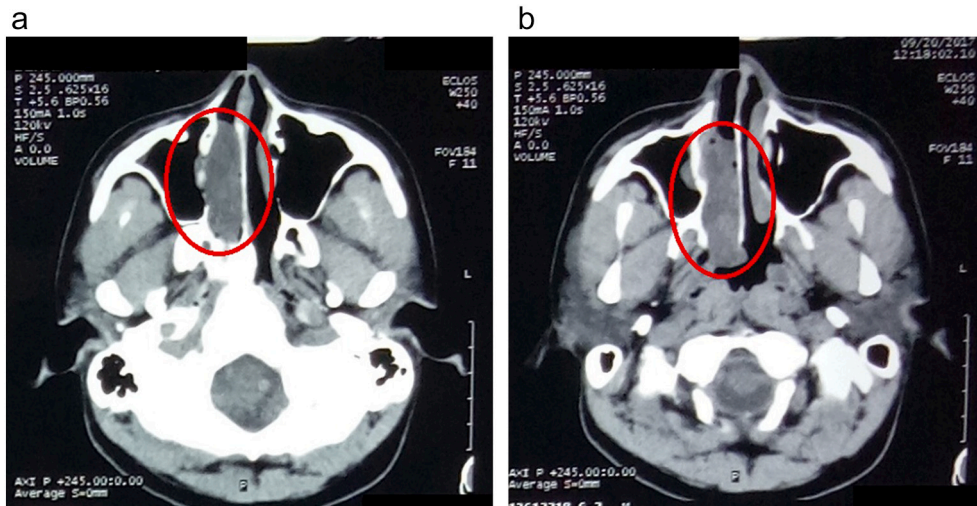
(A–B) CT-scan of paranasal sinuses. A soft-tissue mass in the right nasal cavity expands to the choana (red circle).
